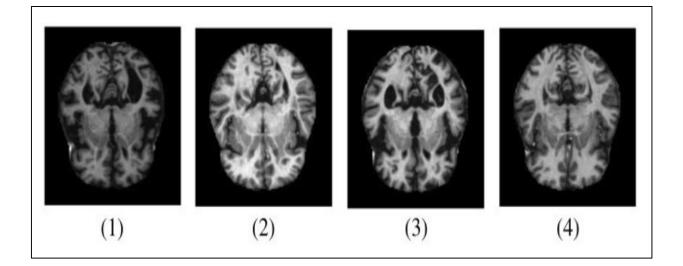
Samples of MRI images representing different AD stages. (1) MD; (2) MOD; (3) ND; (4) VMD (Ghazal, T. M & Issa, G., 2022).
